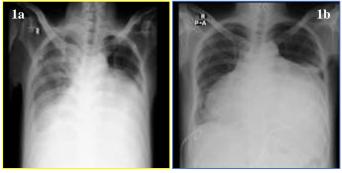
Chest x-rays that show: (a) The chest X-ray shows a normal appearance of the right lung; (b) the chest X-ray reveals an installed pigtail in the thoracic cavity the chest X-ray shows a normal appearance of the right lung.
